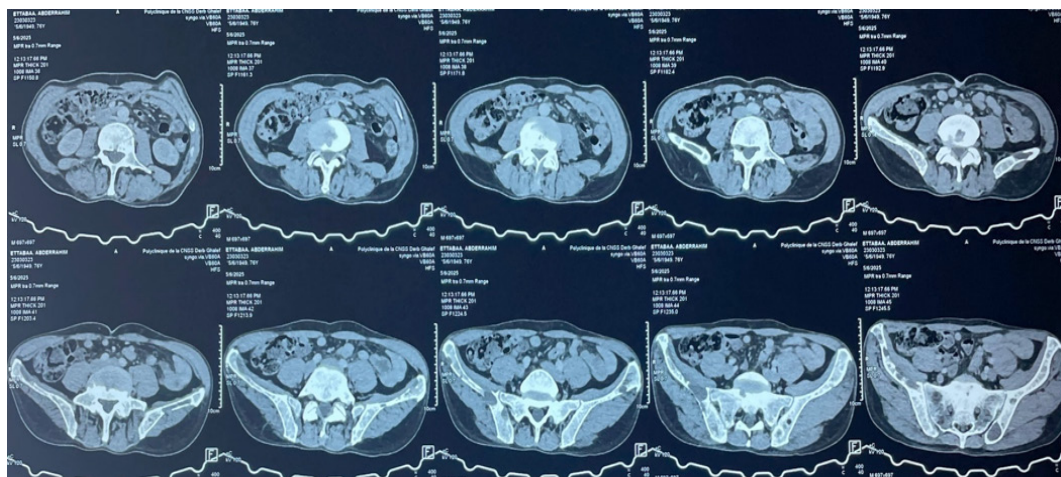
Axial abdominopelvic CT scan showing osteolytic bone lesions involving the spine and the pelvis
